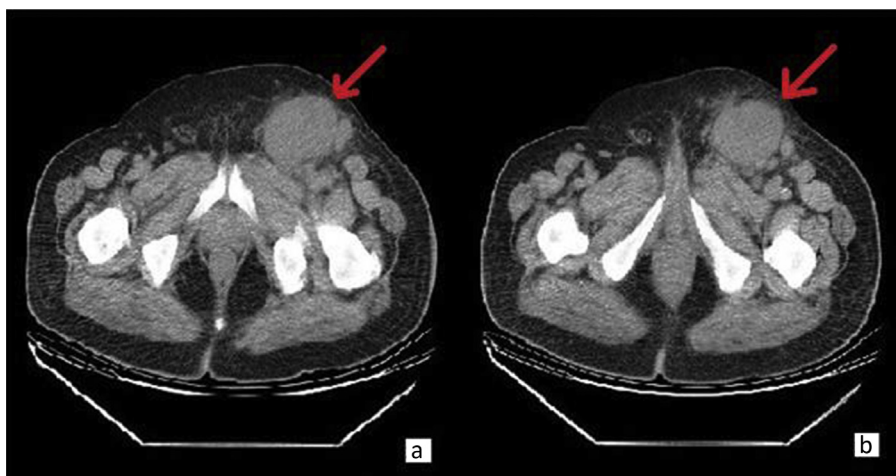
a–b A well-circumscribed hypodense lesion of 72×55 mm in CT.
